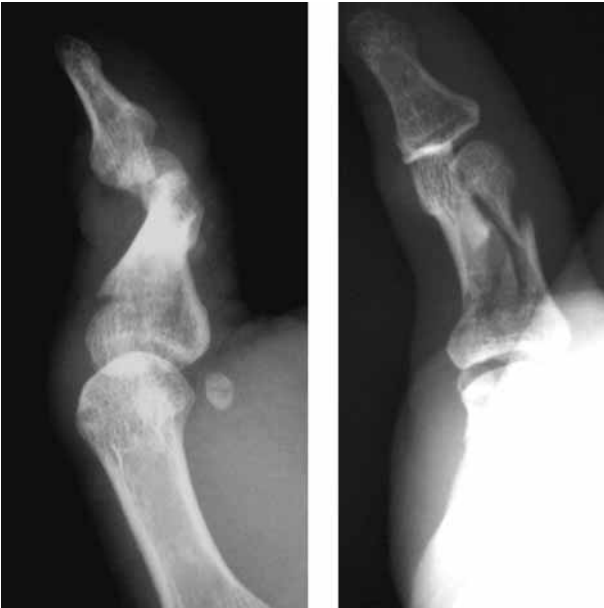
Radiographs showing a comminuted fracture of the proximal phalanx of the thumb with an associated fracture dislocation of the interphalangeal joint.
